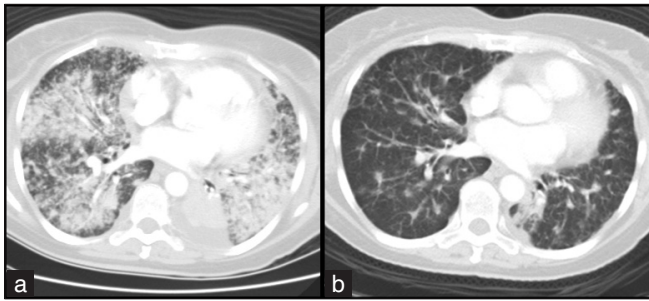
Computed tomography of the chest before (a) and after erlotinib (b)
